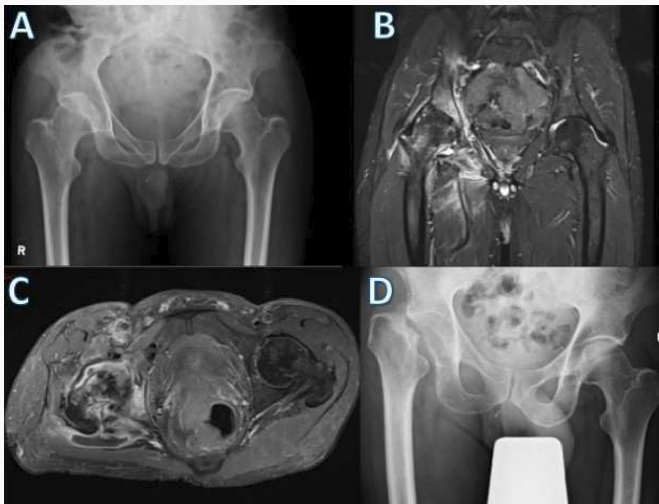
Sequelae of hip sepsis example. a) Initial (total anteroposterior (AP)) pelvis radiograph of 49-year old female at presentation. b) Coronal slice and axial slice. c) Taken from an MRI performed at the same time, demonstrating signal change in the right femoral head indicating bone involvement. d) Postoperative AP radiograph following an excision arthroplasty performed to control the infection.
